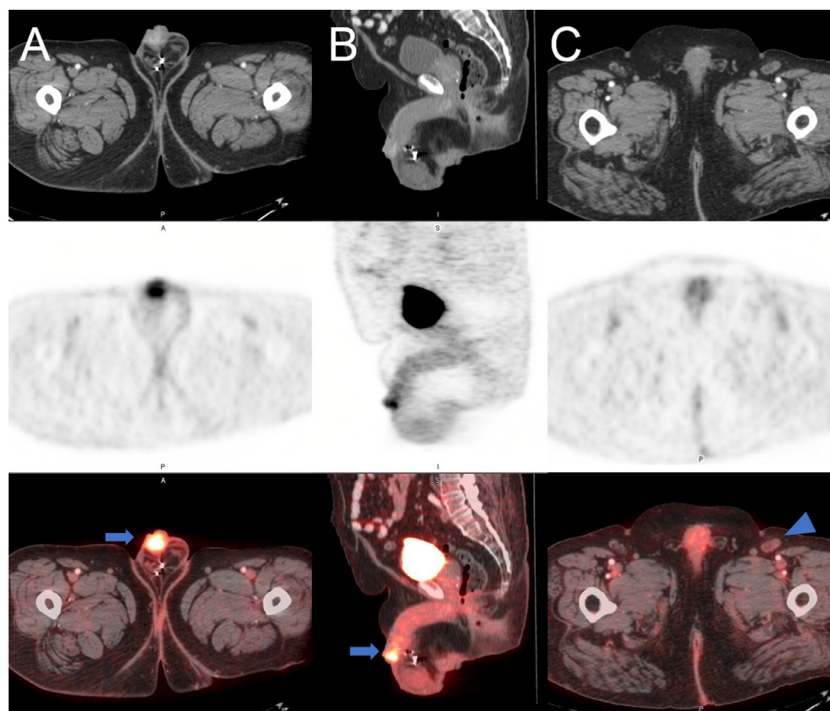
A 65-year-old man was diagnosed with an ulcerated, invasive, and moderate-poorly differentiated, predominantly non-keratinized squamous cell carcinoma of the glans penis. Staging PET/ceCT shows a 2.5 cm contrast-enhancing, FDG avid penile lesion, max. SUV 5.6 (A, axial; B, sagittal; arrow); reference liver SUV was 3.0. A slightly enlarged left inguinal lymph node measuring 1.2 × 2.1 cm shows no abnormal uptake (SUV 1.5), which favors a benign node; there is no PET/CT evidence of distant metastasis. The patient underwent partial penectomy and remains disease-free at his recent 5-year clinical follow-up.
